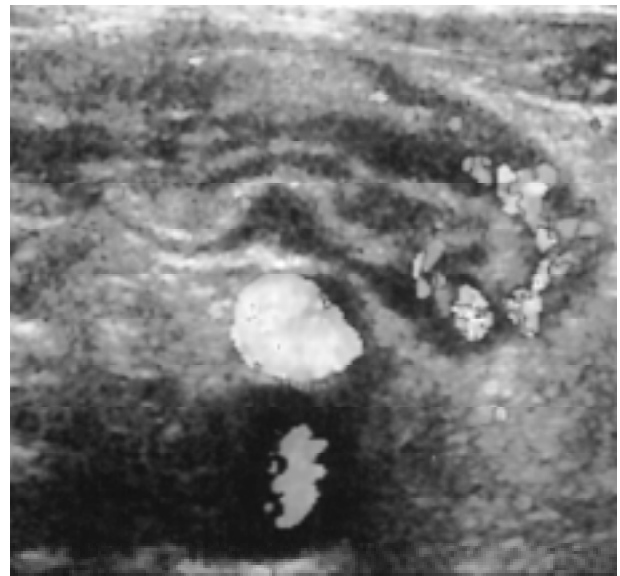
Acute terminal ileitis: a) longitudinal, and b) transverse scan through the terminal ileum shows the symmetrically thickened, hypoechoic intestinal wall; color-flow Doppler shows inflammatory hypervascularization of the intestinal wall and adjacent mesentery.
